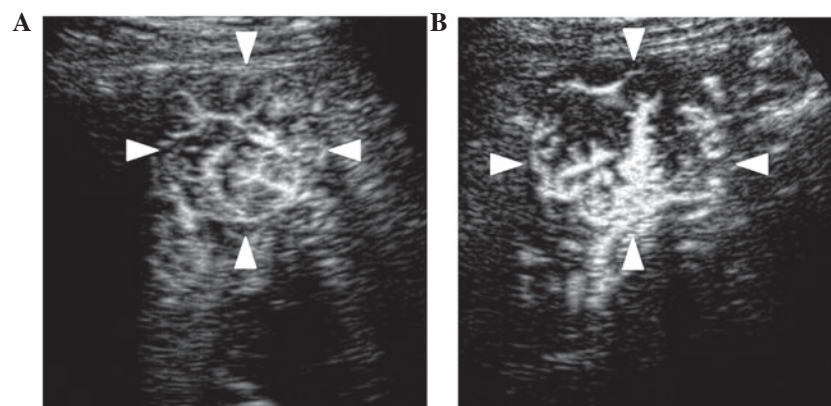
Representative imaging of the Vi group. The patient was a 79-year-old man with hepatitis B virus cirrhosis. Sorafenib administration (400 mg/day) was started for advanced hepatocellular carcinoma. Contrast-enhanced ultrasonography was performed for a tumor in S8 (arrowheads) (A) prior to and (B) 4 weeks subsequent to the sorafenib administration. The intratumoral vascular architecture on the micro-flow imaging findings was thickened and increased subsequent to therapy compared with the vascular architecture prior to therapy.
